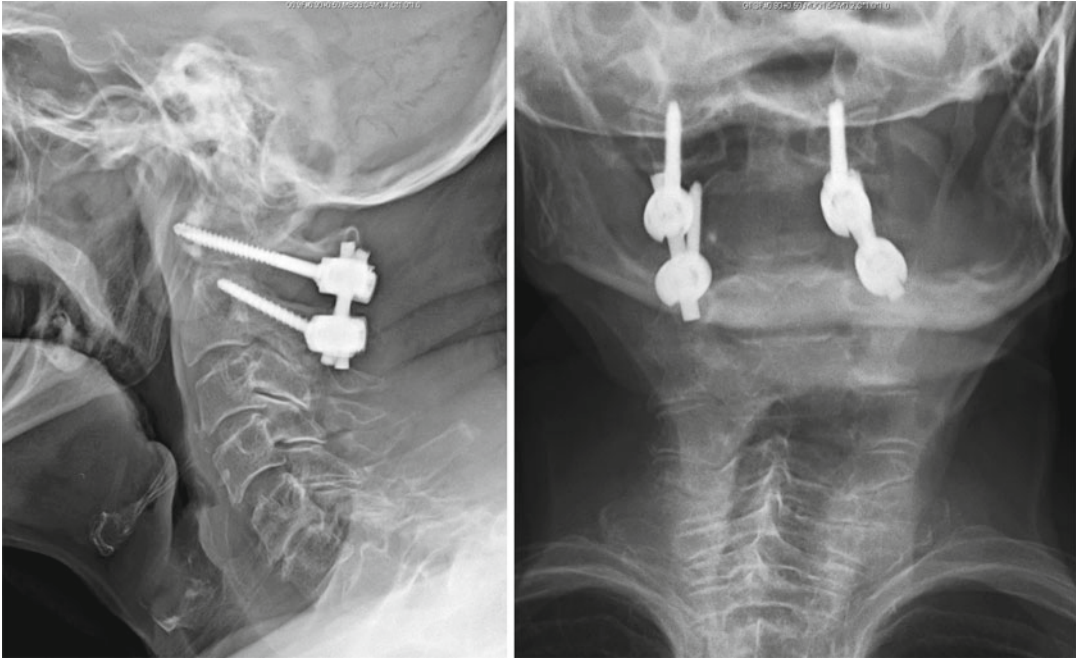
Anterior-posterior and lateral x-rays of the cervical spine status-post C1 lateral mass and C2 pars screw instrumentation
